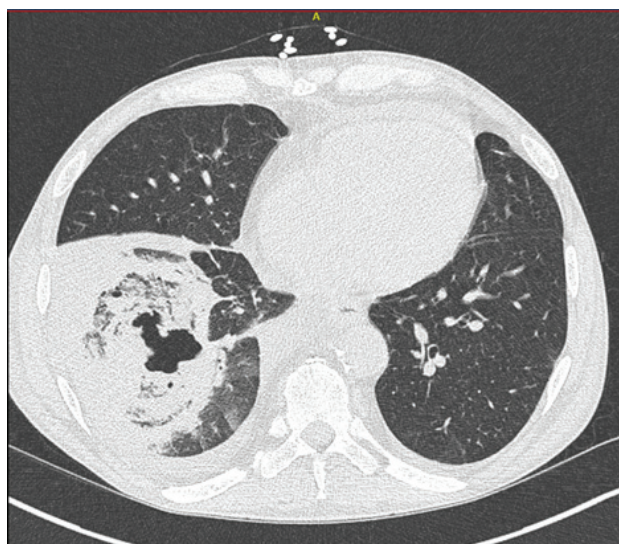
CT chest: evolving cavitating mass.
